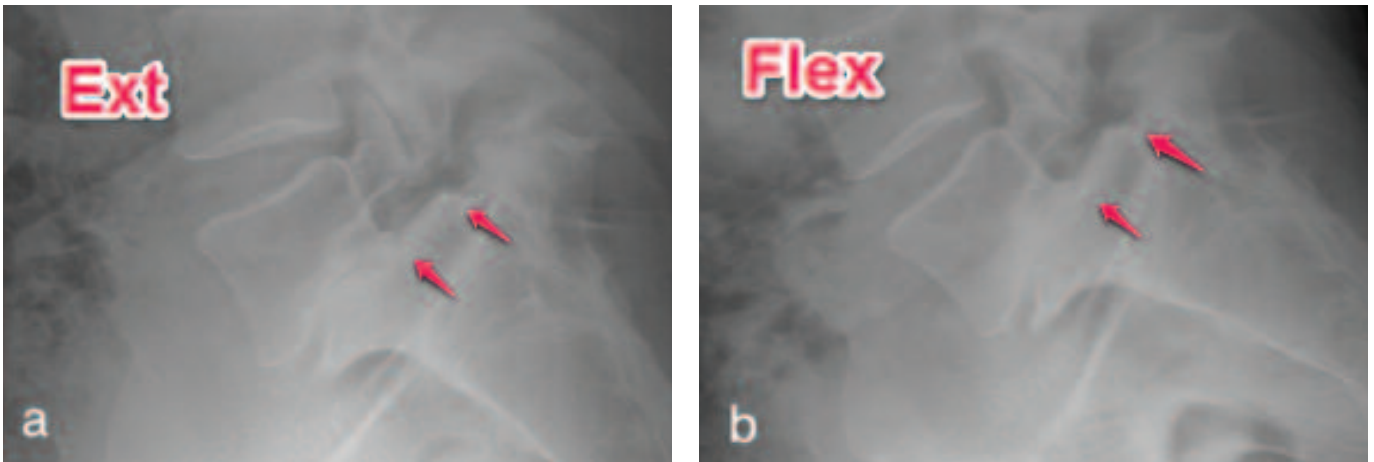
Dynamic lumbar spine X-ray images showed no instability at L5-S1 from extension (a) view to flexion (b) view.
